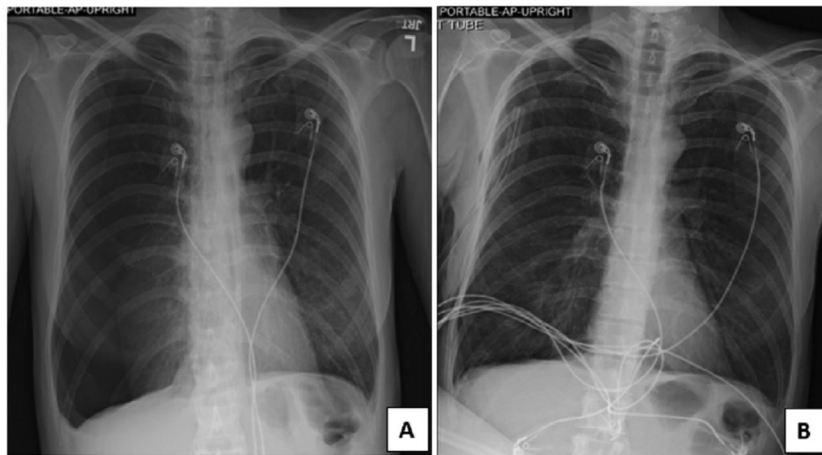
Antero-posterior chest X-ray showing hyperinflated right hemithorax with a large right sided pneumothorax without any mediastinal shift (A). Post tube thoracostomy chest radiography revealed improved pneumothorax. The chest tube was in good position (B).
